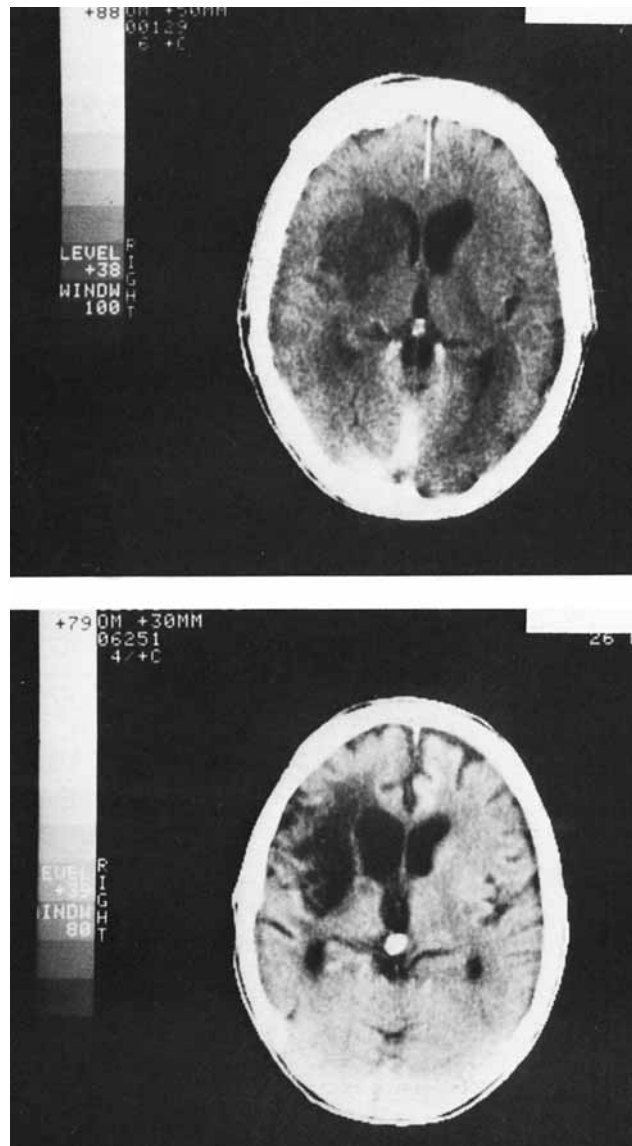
Computed tomography scan of a patient with infarction of the middle cerebral artery territory. (From Hackinski, W, and Norris, JW: *The Acute Stroke*. FA Davis, Philadelphia, 1985, p 194, with permission.)
